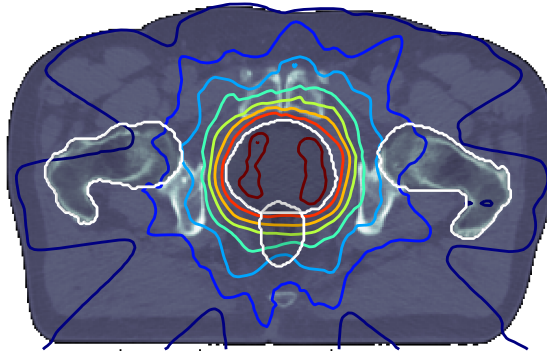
CT image of a prostate cancer patient including the dose distribution of the respective treatment plan shown as iso dose lines. Areas of high dose deposition are displayed in red and orange. Contours of OAR as well as PTV are displayed in white.
